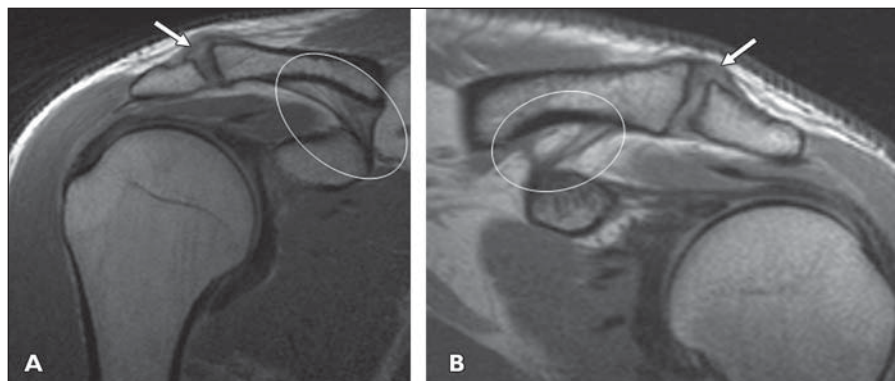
Comparison of Rockwood type I and MRI-adapted Rockwood I+ injuries. A, 27-year-old man after right-sided acromioclavicular joint trauma with Rockwood type I injury. Coronal proton density-weighted image (TR/TE, 1500/25) shows partial tear of superior portion of acromioclavicular ligament (arrow) and normal coracoclavicular ligaments (ellipse). B, 25-year-old man after left-sided acromioclavicular joint trauma with adapted Rockwood type I+ injury. Coronal proton density-weighted image (TR/TE, 1500/25) shows partial tear of superior portion of acromioclavicular ligament (arrow) and partial disruption of coracoclavicular ligaments (ellipse) with attenuated fibers of trapezoid and conoid portions.
